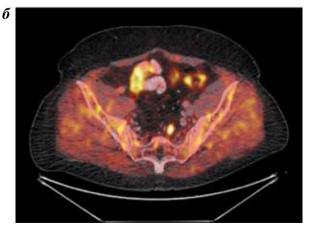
Positron emission tomography coupled with computed tomography: a - patient B, 62 years, with lymphogenic progression of the disease after radical prostatectomy in September of 2011; 6 - patient G, 57 years, with lymphogenic progression of the disease after radical prostatectomy in March of 2011
